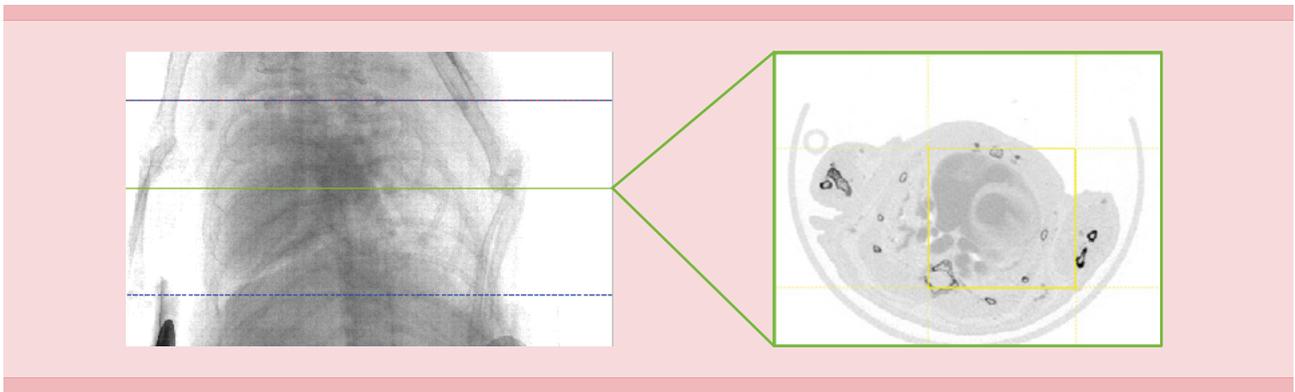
Preview CT images showing the selected anatomical region for reconstruction via positioning of the FOV (blue lines) in the coronal image (left) and the yellow bounding box in a transverse image (green box).
